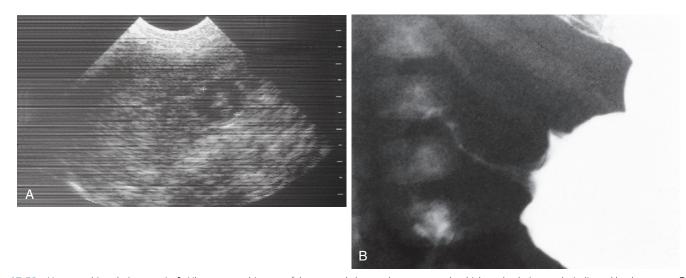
Hypertrophic pyloric stenosis. A, Ultrasonographic scan of the upper abdomen demonstrates the thickened pyloric muscle, indicated by the cursors. B, Barium study of the stomach (*right*) shows thin streaks of barium in the pyloric canal. The hypertrophic pyloric muscle bulged into the gastric antrum produces a "reversed 3" configuration.
